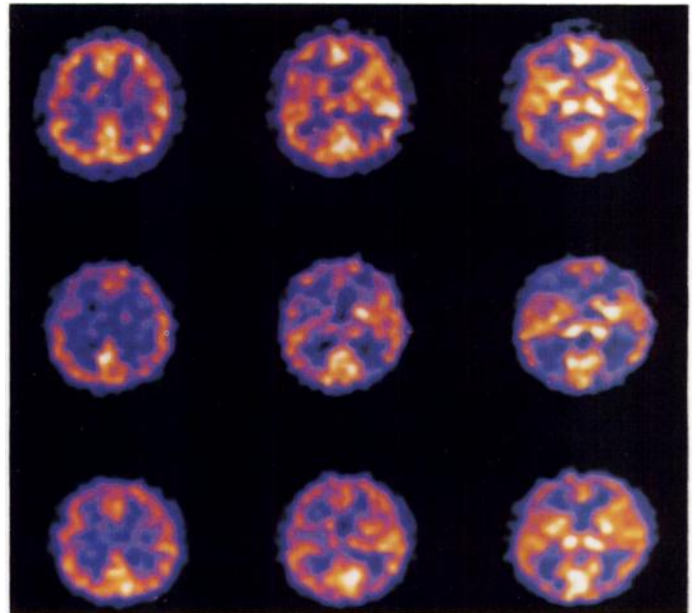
Technetium-99m-HMPAO SPECT axial images of a 58-yr-old patient with CABG. Upper row before surgery, middle row 9 days after surgery and lower row 6 wk after surgery. Bilateral parietal and frontal hypoperfusion is seen 9 days after surgery. (The patient had disorientation, confusion and agitation attacks at this time.) Six weeks after surgery, bilateral parietal and frontal perfusion increased and the patient's symptoms improved.
